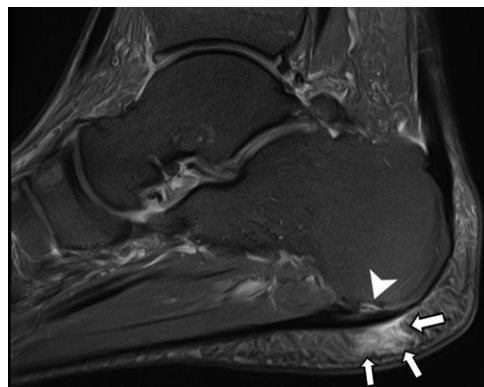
Insertional plantar fasciitis in a 46-year-old woman with AAFD. Sagittal fat-suppressed proton-density-weighted MR image of the heel shows thickening of the central cord and the medial expansion of the plantar fascia at its calcaneal insertion. There is a small focus of altered marrow signal intensity at the enthesis (arrowhead) and overlying plantar fat pad edema (arrows) that is compatible with reactive inflammation. Alignment appears normal on this MR image, although the weight-bearing radiograph (not shown) demonstrated pes planus.
